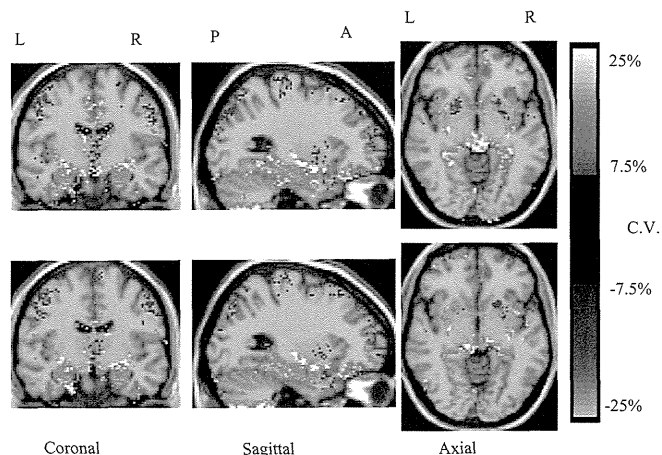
Map of median CVs obtained by VBM Z-score analysis. Top and bottom rows show CV maps for an uncorrected image and a distortion-corrected image (J-ADNI method), respectively. The color-scaled CV map ranges from  $-25.0\%$  to  $-7.5\%$  and from  $7.5\%$  to  $25.0\%$  are displayed by overlaying orthogonal sections of the anatomically standardized MRI. Areas enclosed by green lines show medial temporal structures. Note the decrease in CV following distortion correction for the whole brain.
